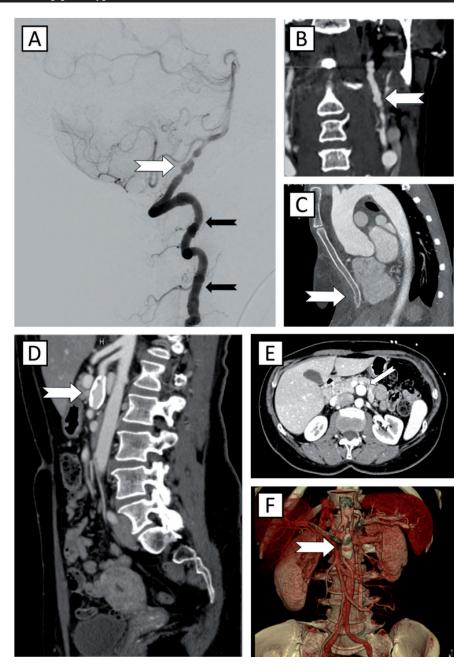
F4 IV-2 with (A) a dissecting growing pseudoaneurysm on digital subtraction angiography of the left vertebral artery in sagittal (white arrow) and presence of corrugated vessel wall indicative of fibromuscular dysplasia (black arrows), coronal CT angiography (B) showing similar corrugated appearance of the left internal carotid artery and sagittal CT angiography (C) demonstrating pectus excavatum. F7 II-1 with a superior mesenteric artery aneurysm (transverse diameter 14 mm; longitudinal diameter 36 mm) on CT angiography (D,E,F).
